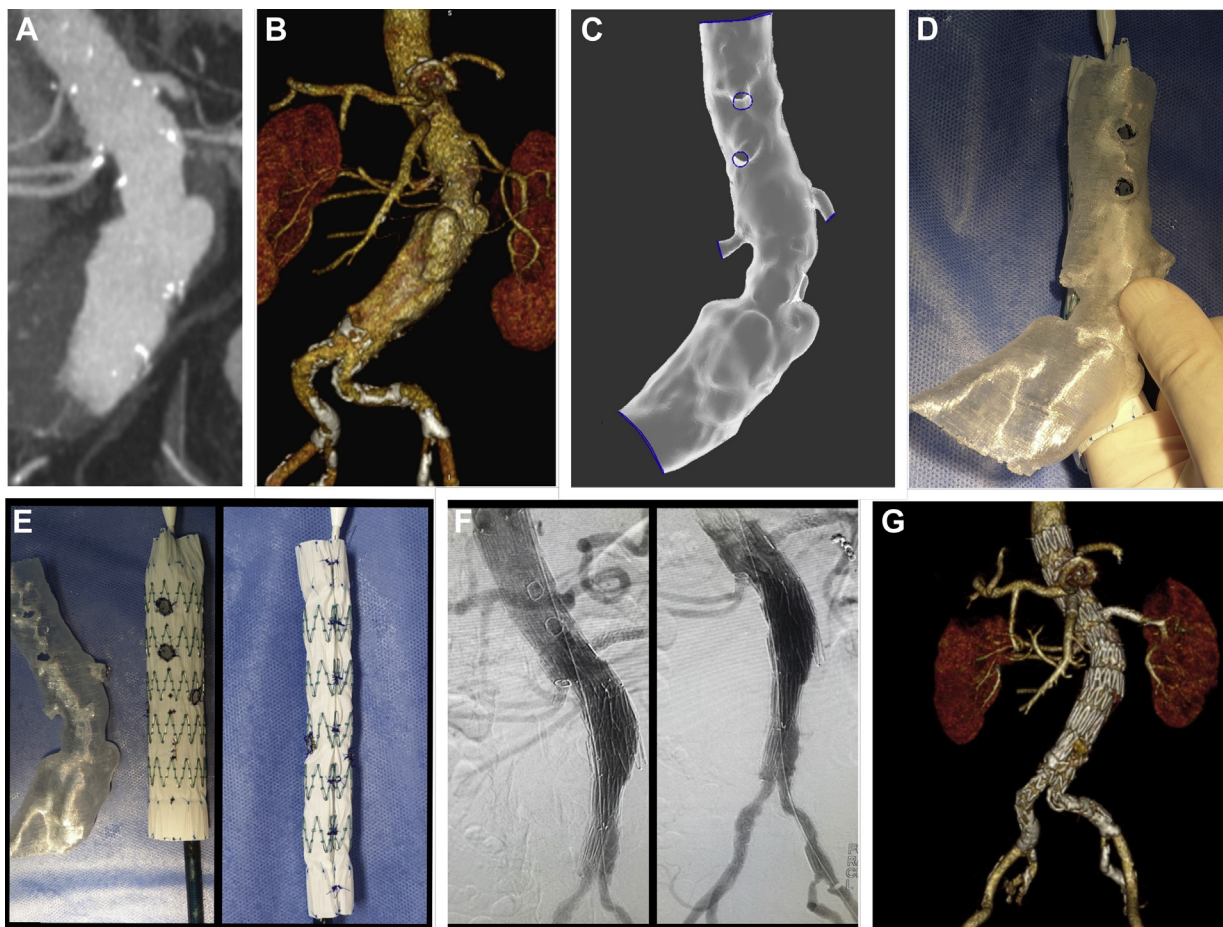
Case 1. Computed tomography (CT) scan shows a 65-mm juxtarenal aneurysm with a healthy visceral aortic segment (A) and suitable anatomy for a fenestrated endovascular repair (B). An aortic three-dimensional (3D) model, created in Meshmixer (C), is printed and sterilized in a relatively short time. The 3D aortic template is used to place fenestrations in a Cook Zenith TX2 device, which is modified on a back table as described by Oderich and Ricotta⁸ (D and E). Final angiographic result after an uneventful procedure and successful cannulation of visceral and renal vessels (F). Follow-up CT scan reveals patent target vessels with no endoleaks (G).
